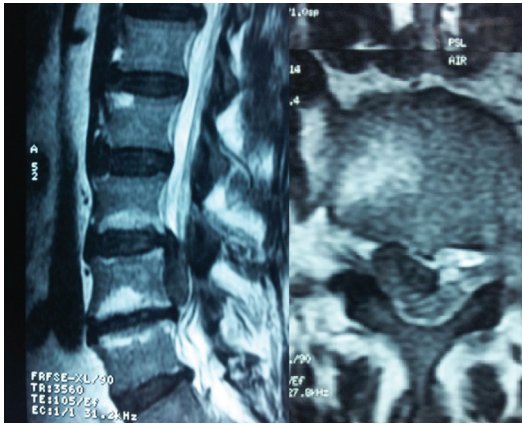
Lumbar magnetic resonance imaging shows a giant, inferiorly migrated, sequestered disc fragment at the right L3-4 level.
